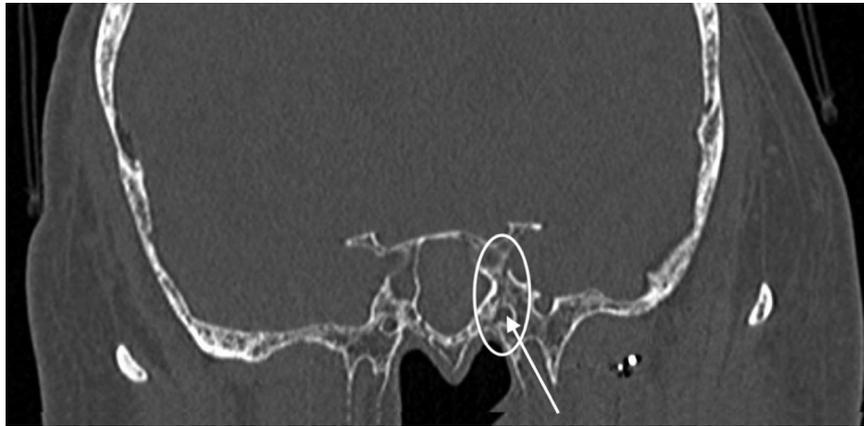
Computed tomography angiography, axial view, bone window. A fracture plane is noted extending vertically from the maxilla through the pterygoid plate toward the sphenoid (white circle). The fracture runs medially to the foramen rotundum (white arrow). The apex of the fracture is traced to the small bone fragment (black circle) in Fig. 1. CA = internal carotid artery
